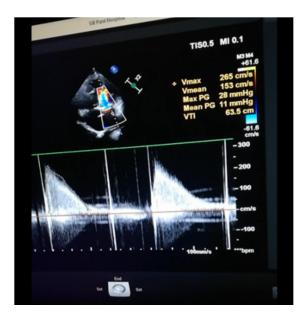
2D Echocardiography image showing high mean and peak gradient across stuck mitral valve
